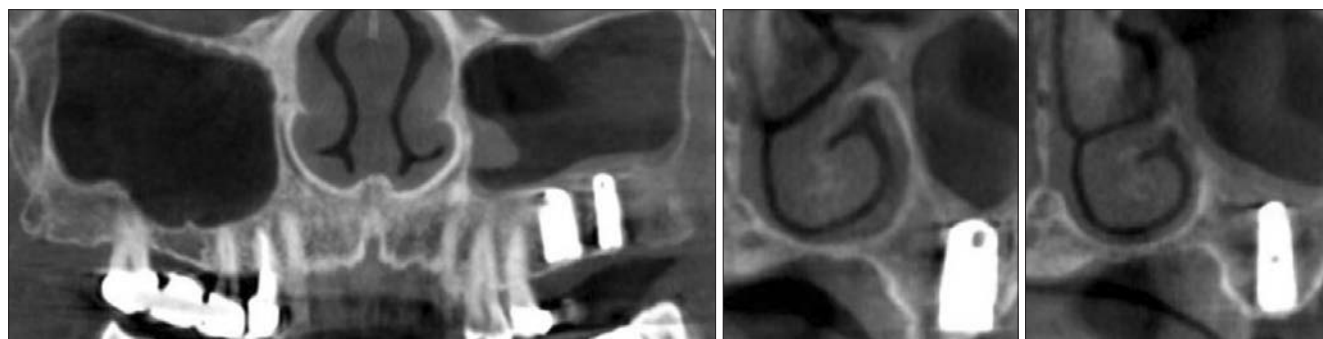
Cone-beam computed tomography showing new bone formation in the sinus after 9 month healing.
